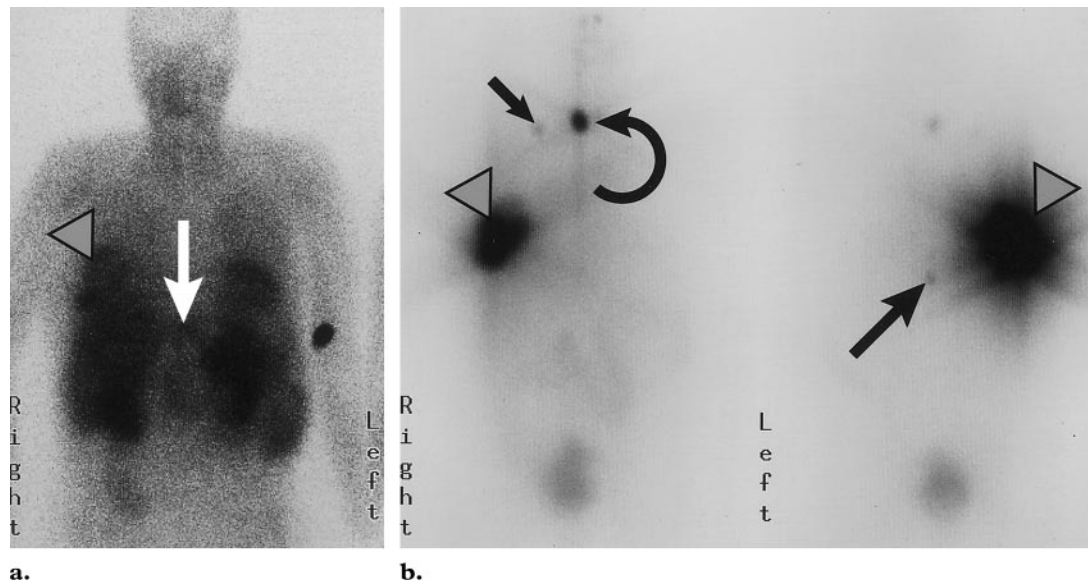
Thyrotoxicosis from metastatic thyroid cancer in a 53-year-old man with a mass compressing the lower thoracic spinal cord and a history of subtotal thyroidectomy for follicular thyroid cancer 5 years earlier (at another institution). Biopsy of the mass revealed metastatic follicular thyroid cancer. Iatrogenic hyperthyroidism from overzealous thyroid suppression with L-thyroxine was the presumptive diagnosis. In preparation for I-131 ablation, L-thyroxine therapy was stopped for 5 weeks. However, the thyrotoxic symptoms persisted; the free T4 level was 2.6 ng/dL, the free T3 level was 752 ng/L, and the TSH level was 0.02 μ IU/mL. Computed tomography (CT) of the chest showed a destructive mass in the right chest wall. The diagnosis of thyrotoxicosis caused by metastatic follicular thyroid cancer was made. I-131 ablation was then considered. Thallium-201 whole-body scanning was performed immediately before I-131 ablation. We eliminated the diagnostic I-131 study to save time (scanning is performed 48 hours after administration of the diagnostic dose of I-131) and to avoid the possibility of stunning by the diagnostic dose. (a) Anterior Tl-201 whole-body image shows metastases in the right chest wall (arrowhead) and thoracic spine (arrow). (b) Anterior (left) and posterior (right) postablation I-131 images obtained 1 week after administration of 200 mCi (7,400 MBq) of I-131 show thyroid bed uptake (curved arrow), a right infraclavicular lymph node (small straight arrow), the chest wall metastasis (arrowheads), and the thoracic spine lesion (large straight arrow).
